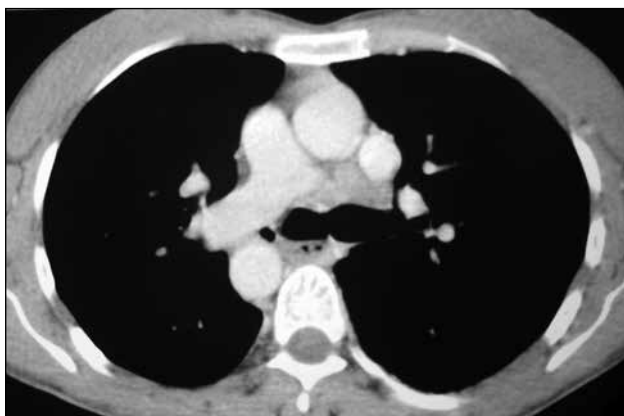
Computed tomographic scan showing reversed placement of large vessels
